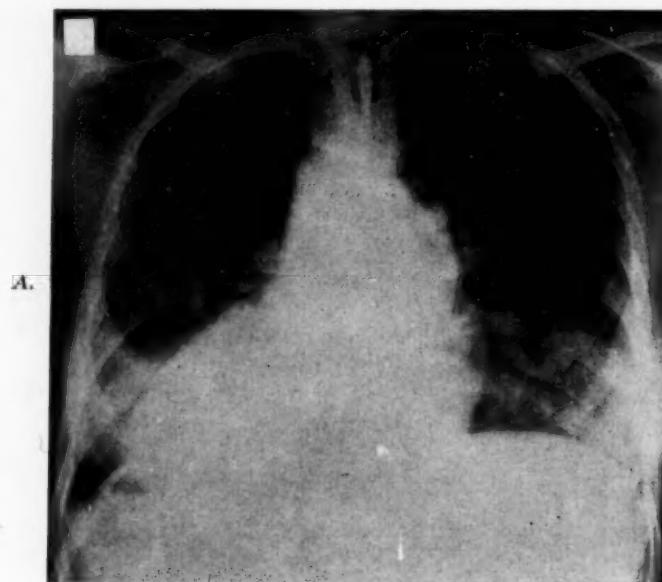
Case 2, P. G.: *A*, Posteroanterior roentgenogram showing situs inversus, combined ventricular hypertrophy, and increased pulmonary vascularity. *B*, Lateral angiogram showing a greatly enlarged azygous vein (*AV*) emptying into the superior vena cava (*SVC*). The column of contrast media is compressed by the enlarged unopacified left atrium (*LA*), and then flows successively into an enlarged right atrium (*RA*), right ventricle (*RV*), and pulmonary artery (*PA*). *C*, Anteroposterior view of *B*, showing the azygous vein (*AV*) coursing upward behind the heart, and then diagonally down and left to empty into the right atrium (*RA*).
